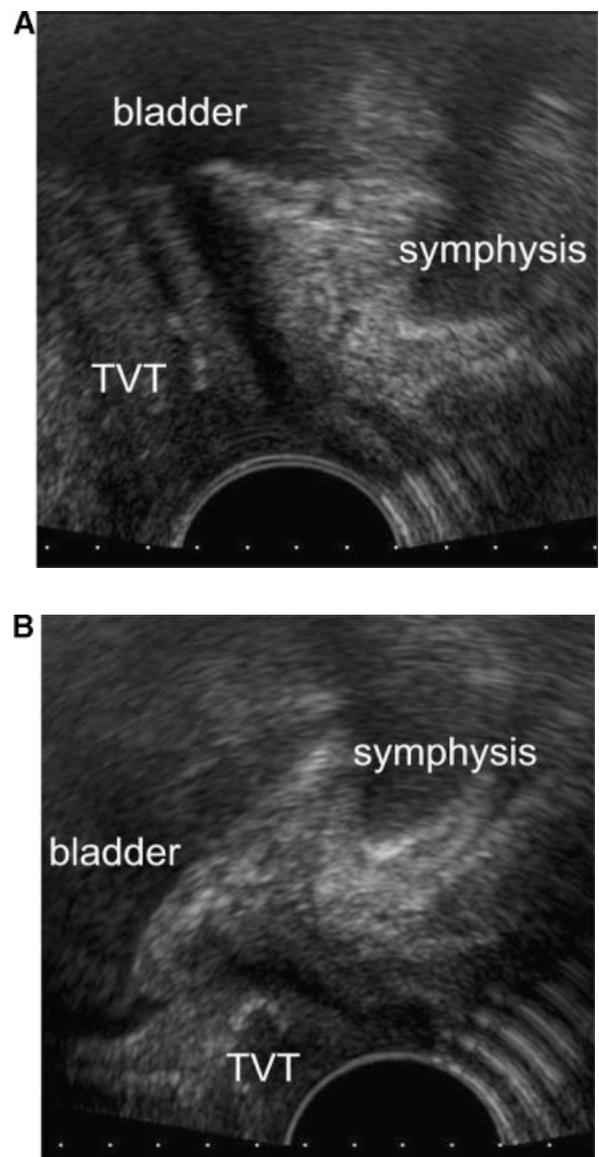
Introital sonography of a continent woman after TVT placement. At rest the tape can be seen as a hyperechoic, flat structure underneath the midurethra in (A). During Valsalva the tape is c-shaped (curved) as shown in (B).
